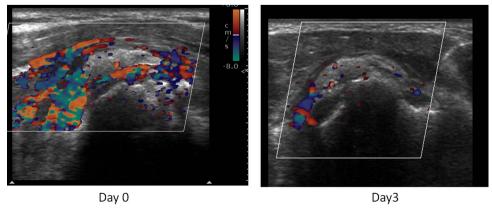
Patient 4: regression of Doppler activity around the calcification from day 0 to day 3.
